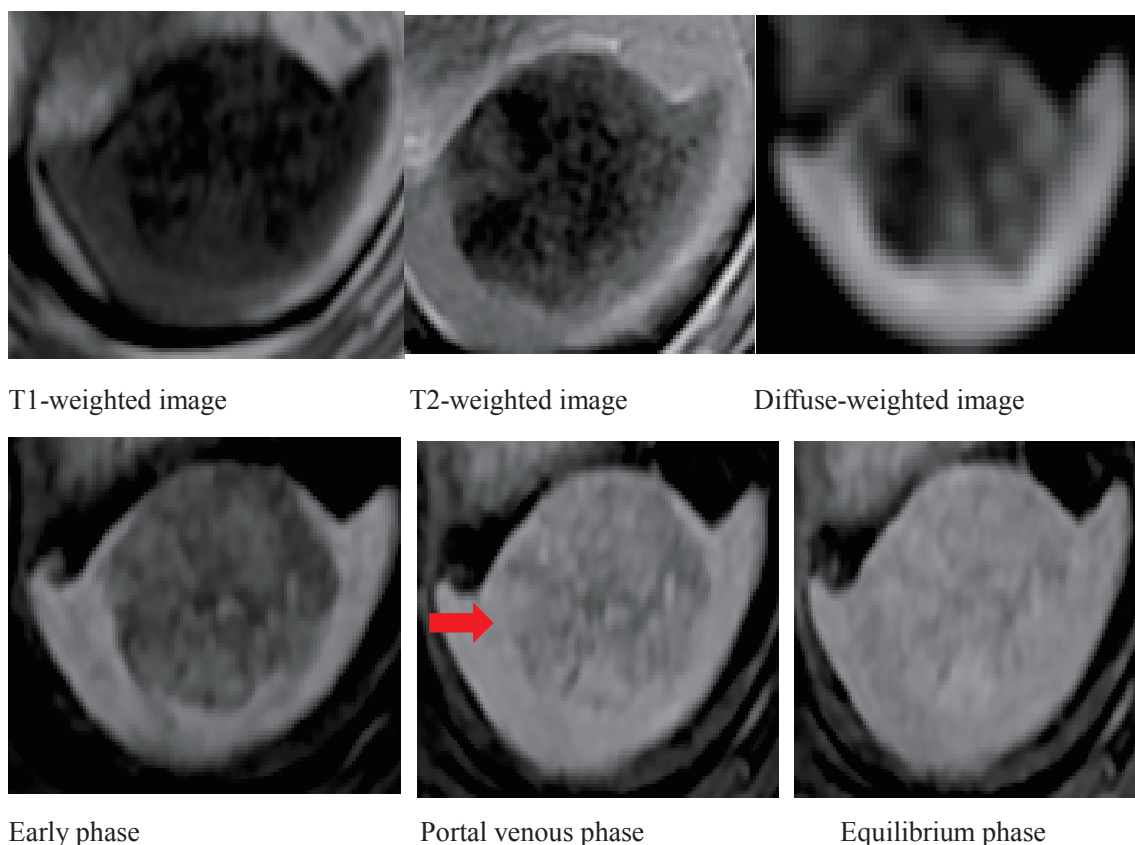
Abdominal magnetic resonance imaging
